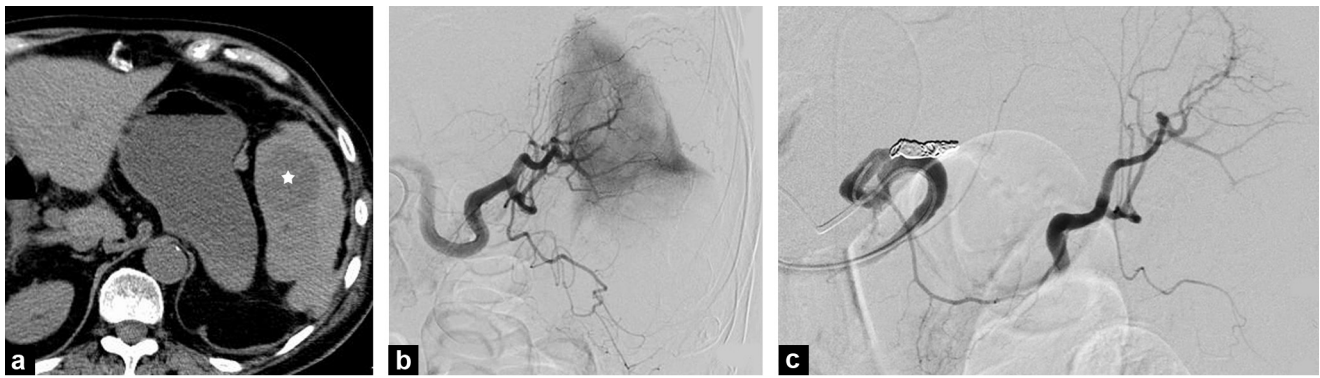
Rupture of spleen metastases of a melanoma: a: abdominal CT without enhancement. Subcapsular splenic hematoma in contact with a spontaneously hypointense intraparenchymal mass (star); b: splenic arteriography. Hypovascular mass in the inferior pole of the spleen appearing as a spur sign; c: splenic arteriography. Post-treatment appearance after proximal obstruction of the splenic artery with coils analogous to the preventative embolization technique for traumatic injury to the spleen at high risk of rupture. Proximal embolization reduces the intrasplenic pressure and avoids infarction because of collateral supply from the gastro-epiploic and pancreatic arcades.
